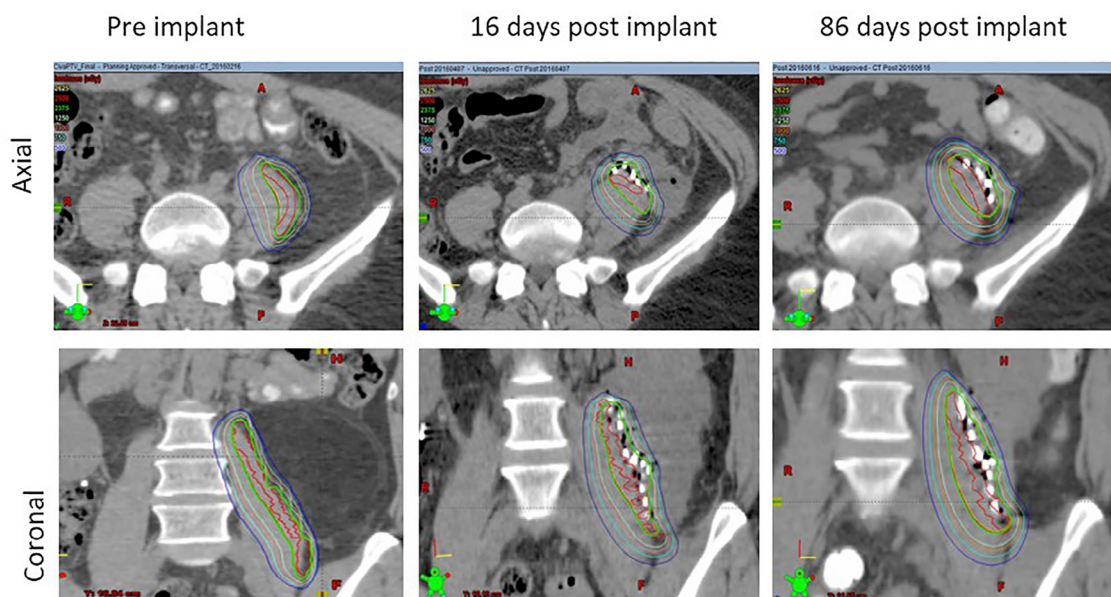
Pre- and postimplant computed tomography studies for patient 1. The isodoses shown are 5.0 Gy (blue), 7.5 Gy (cyan), 10.0 Gy (pink), 12.5 Gy (light green), 23.75 Gy (green), 25.0 Gy (red), and 26.25 Gy (yellow).
